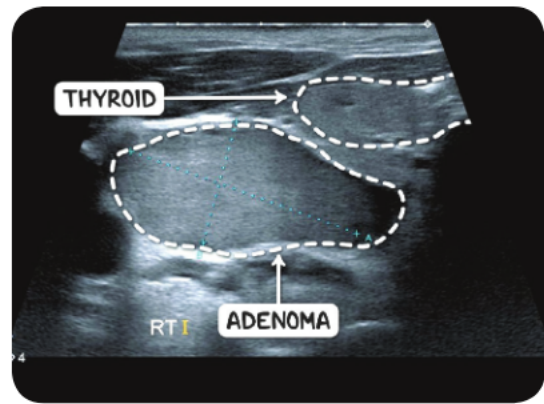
An ultrasound of the neck demonstrating a large parathyroid adenoma situated posteriorly and to the right of the right thyroid lobe. The skin surface is at the top of the image.
